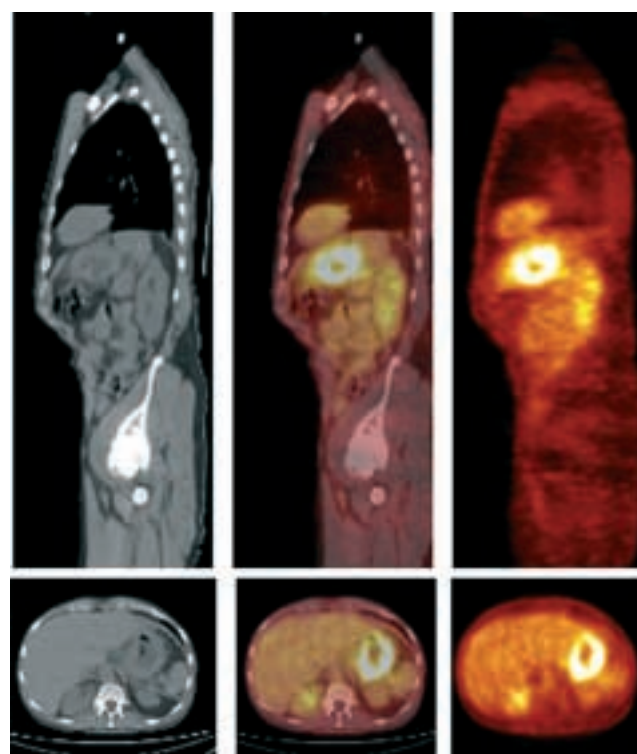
Staging of gastric cancer: 62-year-old woman with adenocarcinoma of the stomach. Coronal (*top*) and transaxial (*bottom*) CT, PET/CT fusion, and PET images of the torso demonstrate intense increased FDG uptake in the wall of the stomach. There is no evidence of locoregional or distant metastatic disease.
